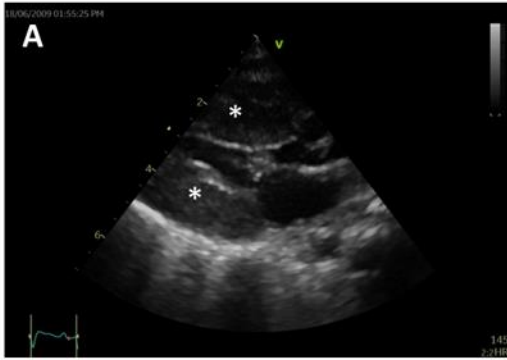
Echocardiographic images of patient 5, Related to Figure 1. Transthoracic echocardiographic imaging of patient 5 (Noonan syndrome, *PTPN11*, male, 2 months of age) at the time of admission to the hospital for surgical left ventricular outflow tract resection (panel A – D). Depicted are the parasternal long axis view (panel A), parasternal short axis view (panel B), and the apical 5-chamber view (panel C and D) with color Doppler (panel C) and continuous wave (CW) Doppler (panel D) imaging. There is severe myocardial thickening (*), the peak gradient over the left ventricular outflow tract measures 85 mmHg. At 76 months of age (panel E – H), myocardial hypertrophy was much less pronounced (* in panel E), but there was a remaining spur in the left ventricular outflow tract below the aortic valve (# in panel F) causing a localized obstruction (§ in panel G) with a gradient of up to 118 mmHg (panel H). The patient underwent a second surgical resection of this left ventricular outflow tract spur at this point. Follow-up at 109 months of age showed enddiastolic myocardial wall thickness z-score within the normal range and no outflow tract obstruction (panel I and J).
